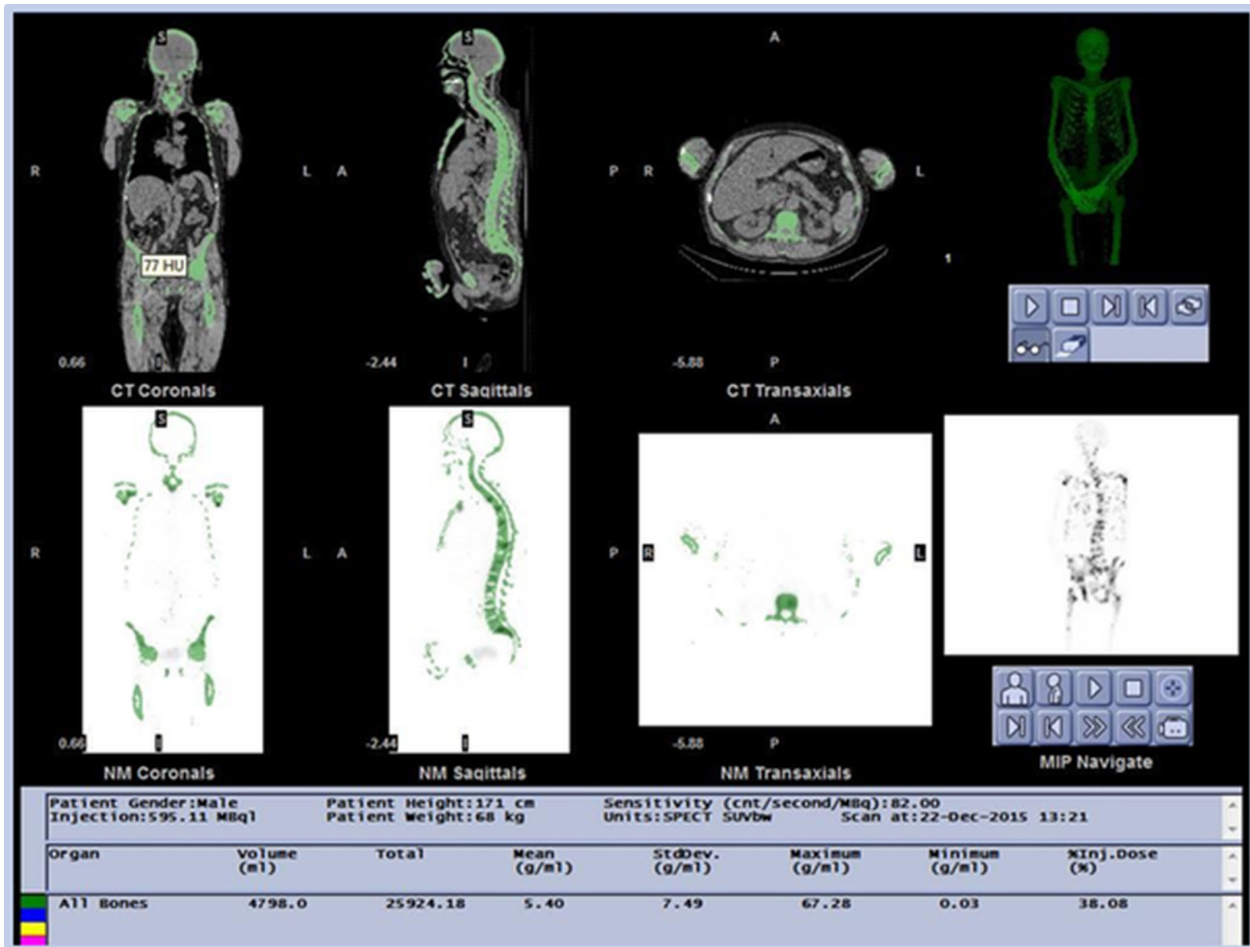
The bone compartment as defined by CT and quantitative data for 99mTc-DPD uptake in a mCRPC patient with osseous metastases.
